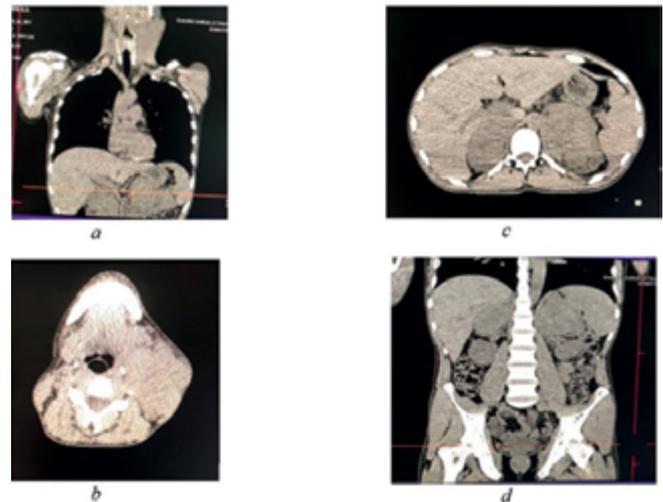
Multispiral CT before treatment of patient M, 56 years old: (a) Multispiral CT of the chest area before treatment; (b) Multispiral CT of the neck before treatment; (c) Multispiral CT of the abdominal cavity before treatment; (d) Multispiral CT of the abdominal cavity before treatment.
